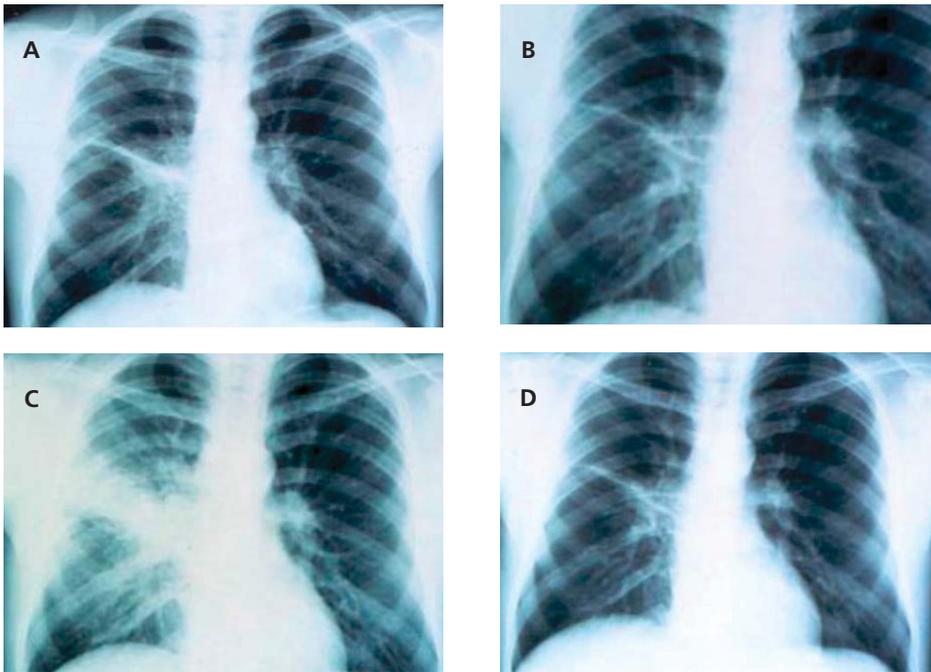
(A) Initial chest x-ray of patient with tuberculosis shown in Figure 2. (B) Improvement after 1 month of 4-drug antituberculosis therapy. (C) After 1 month of potent antiretroviral therapy; apparent worsening of disease reflects increased inflammatory response associated with immune reconstitution under antiretroviral therapy. (D) One month later, after response to anti-inflammatory medication.
